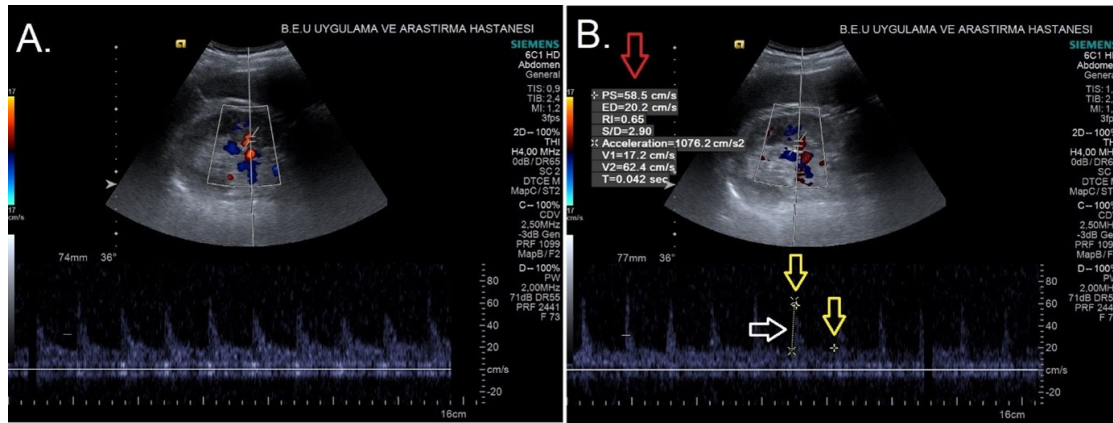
Measurement of Renal Resistive Index by renal doppler ultrasonography. A, Renal color and spectral Doppler at interlobar artery. B, Renal Resistive Index (RRI) and Acceleration Time (AT) measurements, the white arrow shows AT, the yellow arrows show RRI, and the red arrow shows automated calculations which ultrasound device made.
